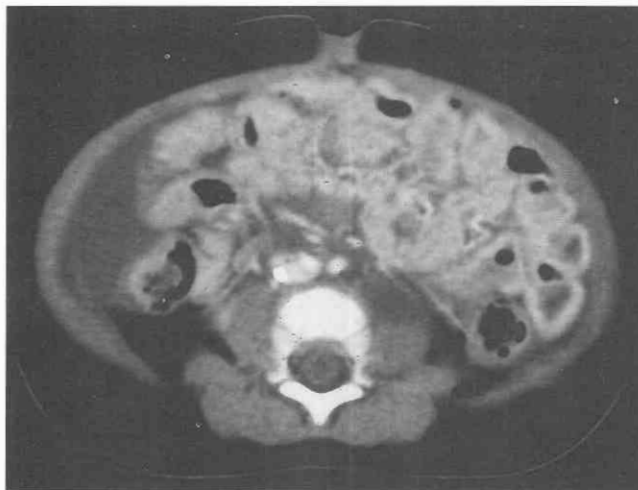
Unclotted hemoperitoneum. CT scan through the midabdomen of a patient with hepatic injury following blunt abdominal trauma demonstrates low-attenuation, free hemoperitoneum in the right paracolic recess.
